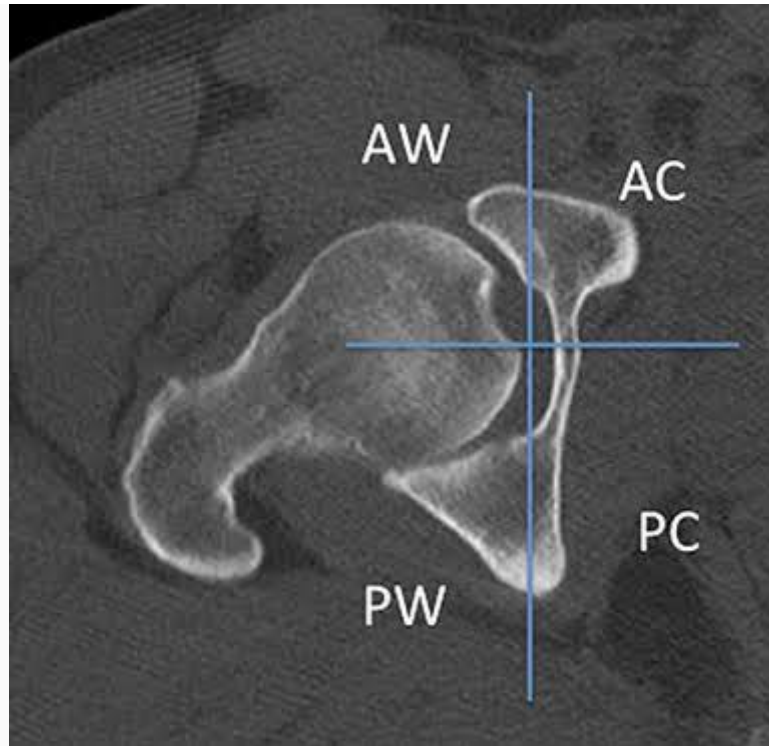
CT Axial cut showing the different acetabular fracture pattern
